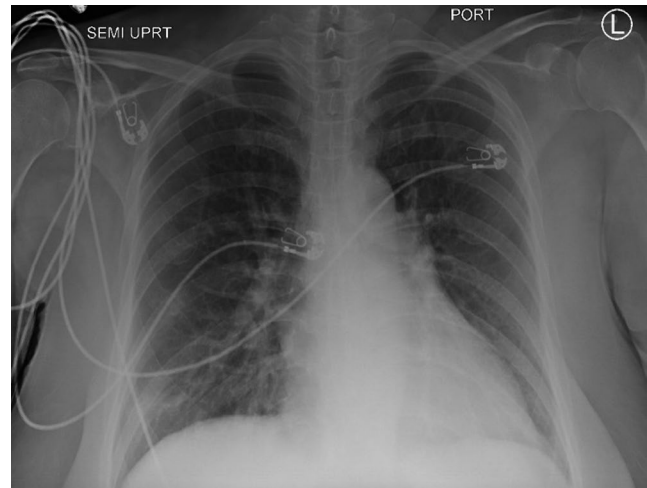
A chest x-ray frontal view on the day of admission reveals bibasilar atelectatic changes, with possible patchy consolidation in the right middle and lower lung zones. There is peribronchial cuffing. There is mild pulmonary vascular congestion
